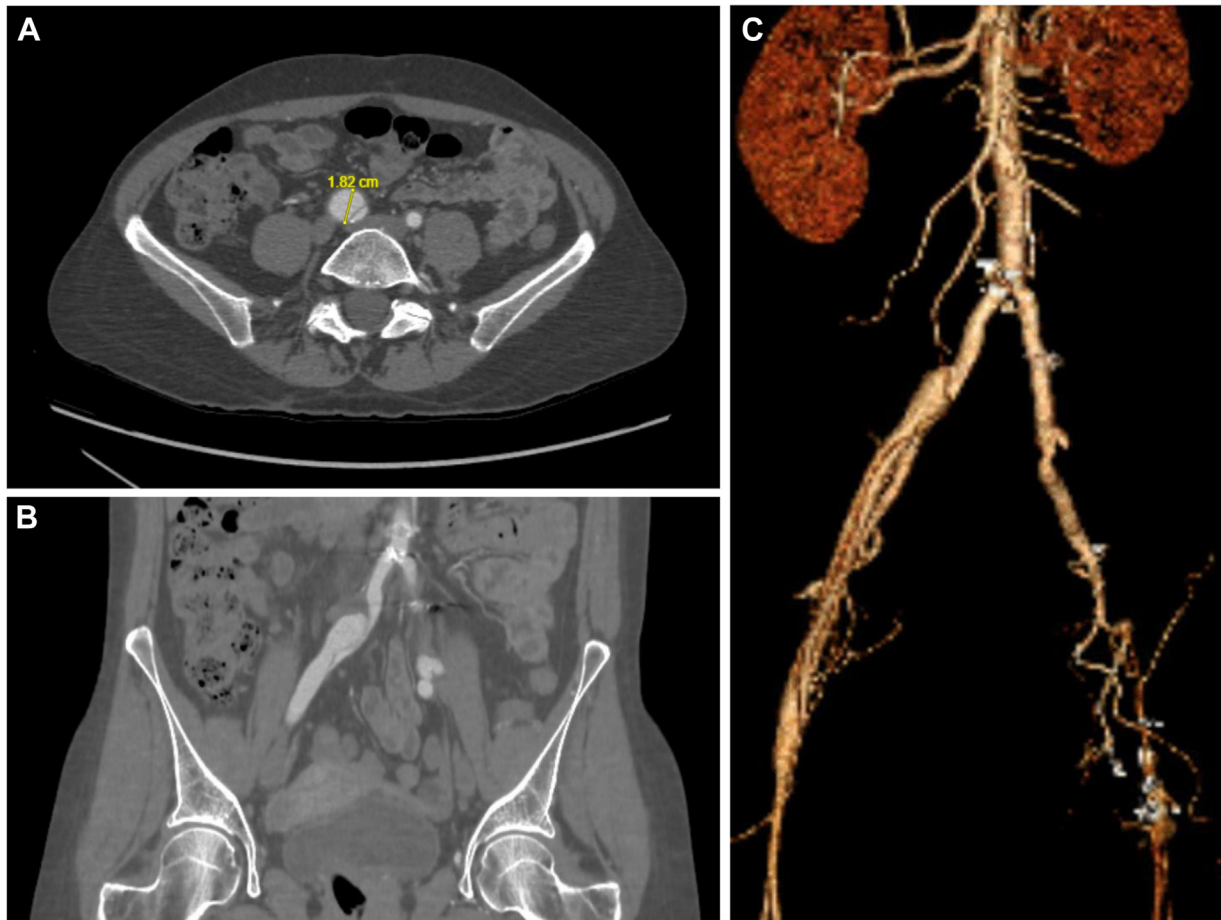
Computed tomography angiography (CTA) of the patient. Axial (A) and coronal (B) projections demonstrating the dissected right common iliac artery (CIA) aneurysm measuring 1.8 cm in maximum diameter. C, Three-dimensional reconstruction of patient's vascular anatomy, including previously repaired left iliac artery with an aorta to right internal iliac artery (IIA) bypass and dissected distal right CIA.
